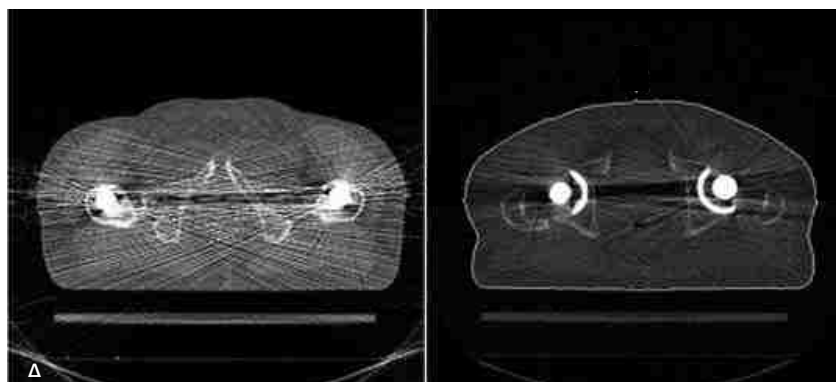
A transverse pelvic CT slice through a patient's hip prostheses (A) before and (B) after metal artifact reduction (Yazdia, et al., 2005).
